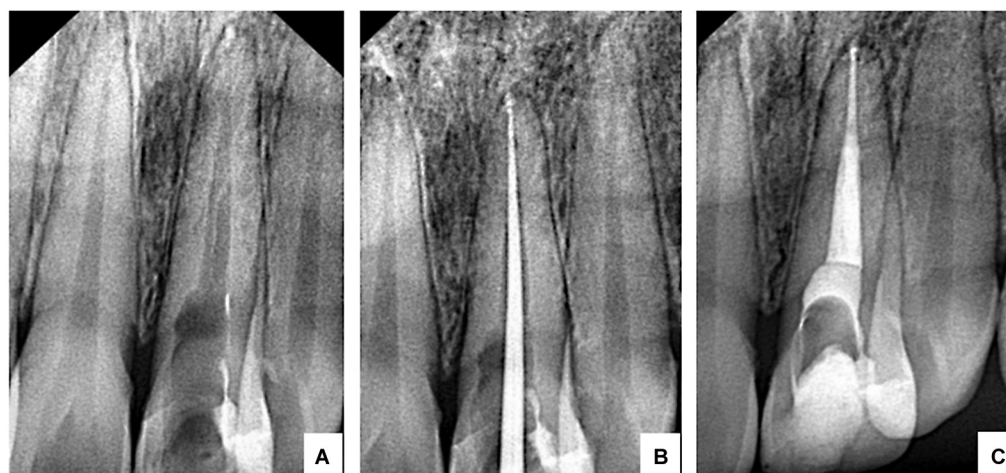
(A) Radiograph after removing obturation material on tooth no 21, (B) Master Apical Cone (MAC) confirmation radiograph, and (C) radiograph after obturation on tooth no 21.
